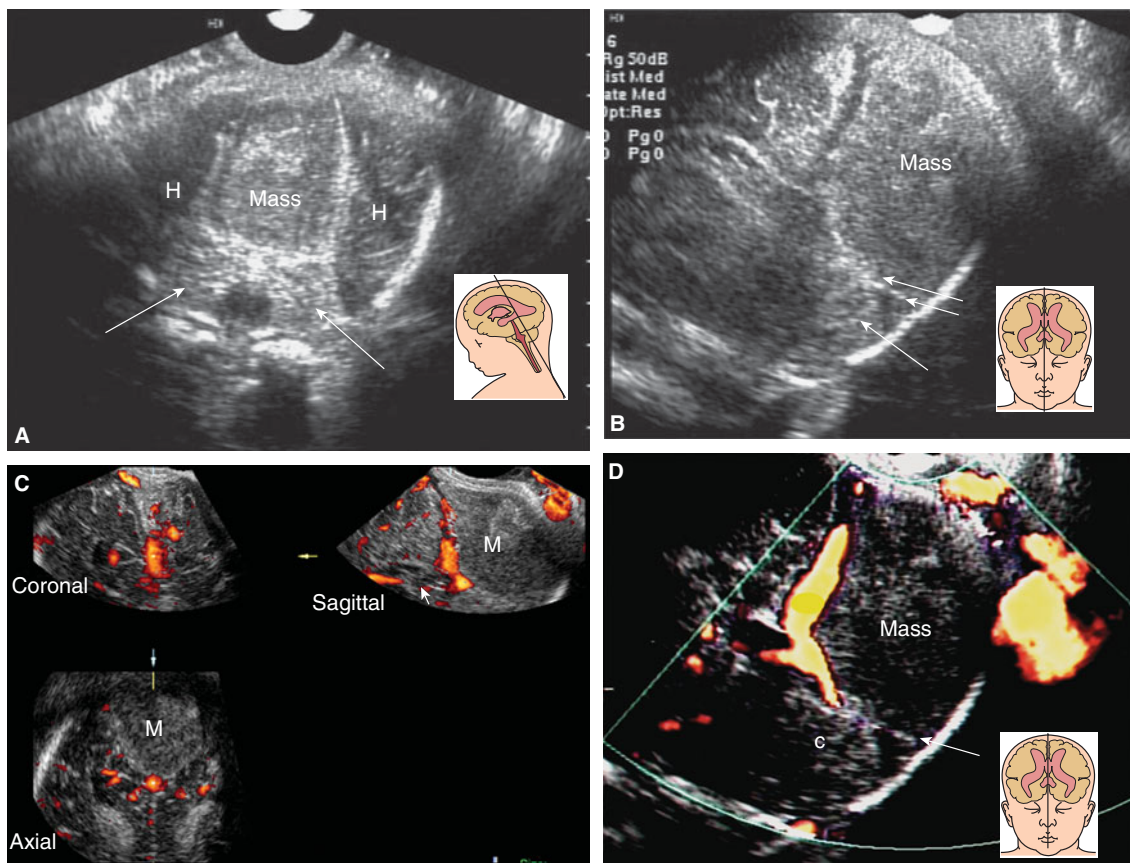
Another case of thrombosis of the torcular herophili at 38 postmenstrual weeks. The neonate died hours after delivery. (A) Posterior coronal plane. The mass displays the hemispheres (H). The arrows point to the cerebellum. (B) Sagittal section demonstrating the pressure of the mass on the posterior fossa and the cerebellum (arrows). (C, D) 3D power Doppler image showing displacement of the vessels by the mass (M).
